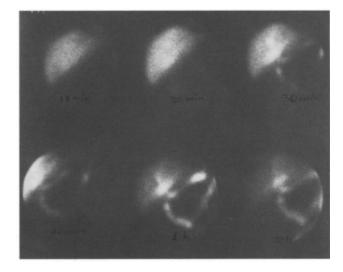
Normal cholescintigraphy, en-series.
